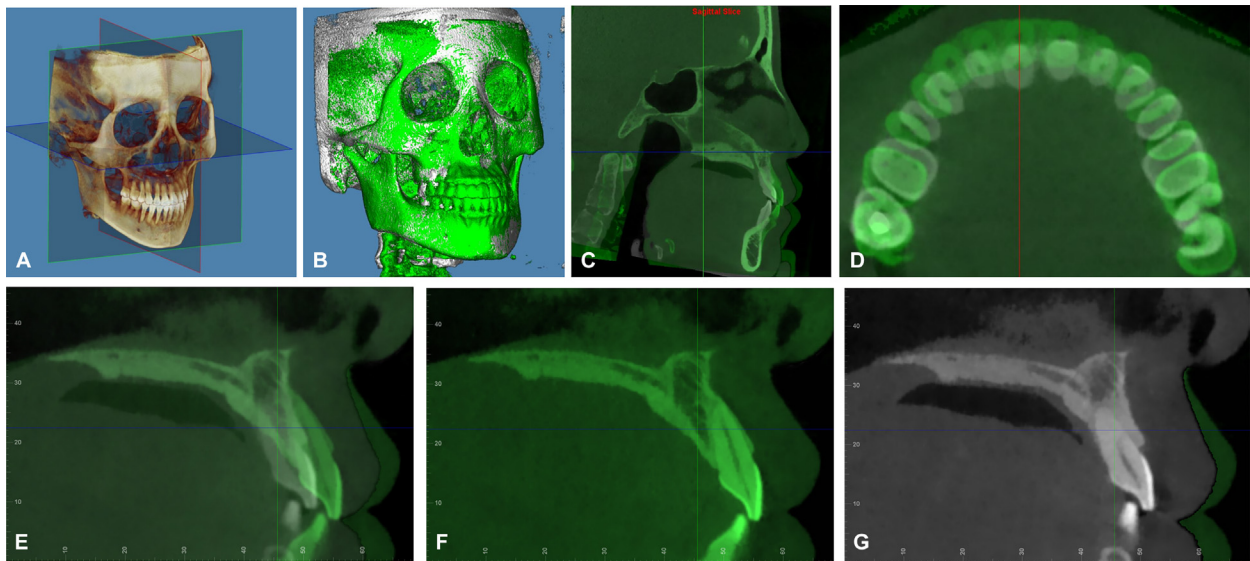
CBCT data processing in Dolphin Imaging software: A, Head position; B, T0 (*green*) and T1 (*white*) CBCT scans superimposition results, consistent with the anterior cranial base; C, Palatal plane (ANS-PNS) was the axial plane; D, Red indicates the sagittal slice passing through the cross-section for center points of T0 and T1 incisors; E, Superimposed sagittal slice; F, T0 sagittal slice; G, T1 sagittal slice.
